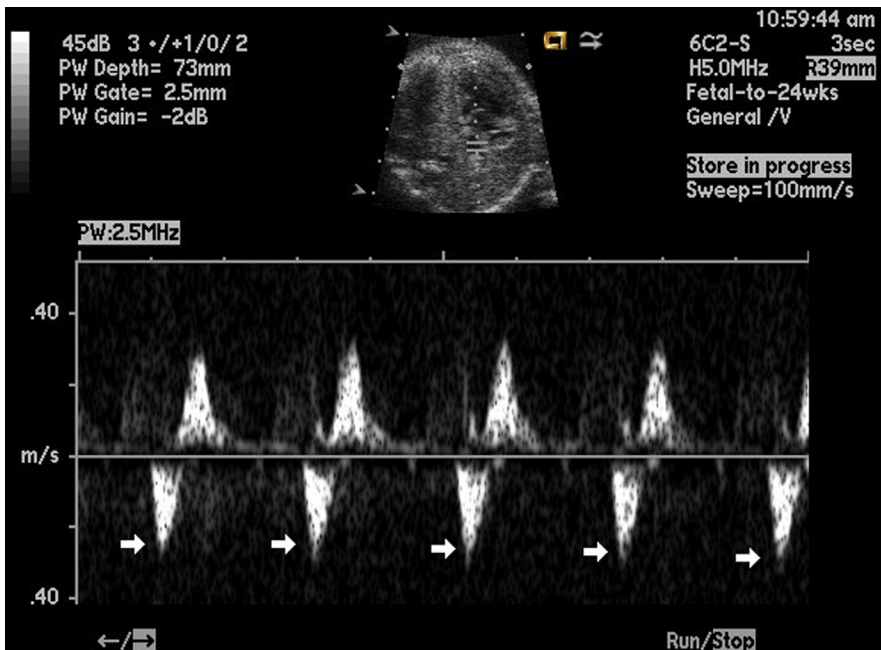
Doppler interrogation of the pulmonary veins showing that the pattern of pulmonary venous flow in HLHS has correlated well with left atrial hemodynamics. Arrow demonstrates prominent reversal wave in pulmonary veins with atrial contraction.
